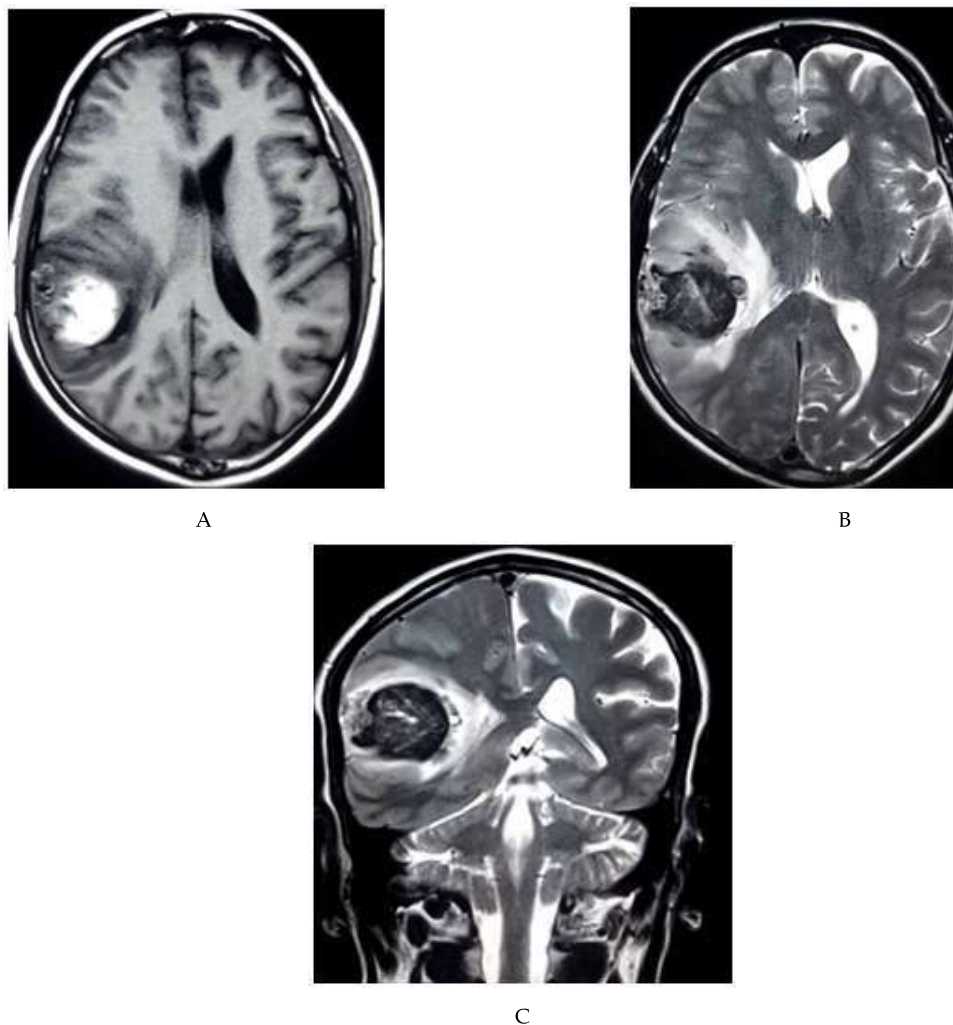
(A) MRI of brain; (B) T1WI axial section showing a mixed intensity lesion within the parietal lobe causing compression of lateral ventricle; (C) Lesion become heterogeneously hypointense with multiple flow voids.
